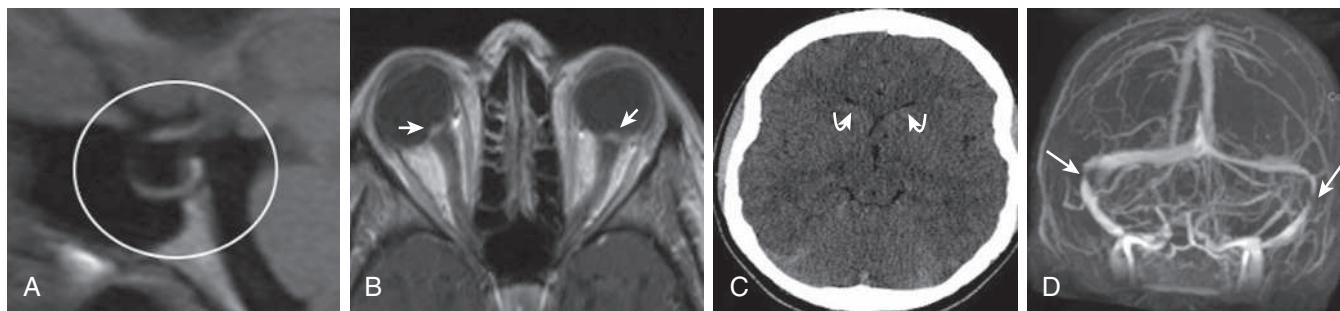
Female with idiopathic intracranial hypertension. A, Sagittal T1-weighted image shows a partially empty sella. The pituitary gland is flattened against the floor of the sella, and the rest of the sella is filled with CSF (circle). B, Axial T1-weighted postgadolinium image of the orbits demonstrates protrusion of the optic disc heads into the vitreous, with associated enhancement (arrows). C, Axial head CT (shows slitlike appearance of the lateral ventricles (arrows). D, Coronal CE-MRV MIP image shows focal stenosis at the junction of the transverse and sigmoid venous sinuses (arrows). (From Guarnizo A, Albreiki D, Cruz JP, et al. Papilledema: a review of the pathophysiology, imaging findings, and mimics. *Can Assoc Radiol J*. 2022;73:557–567, Fig. 2, p. 560.)
